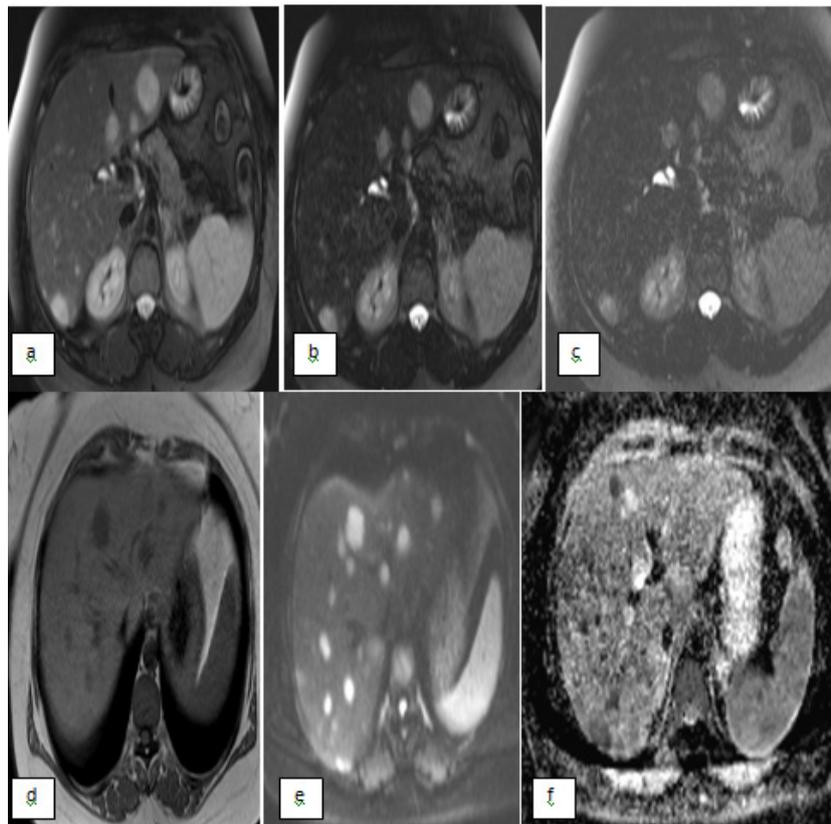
Increasing TET2 weighted images (a, b, c) in a patient with known carcinoma colon and a solitary lesion on USG. With increasing TE, the signal intensity of the lesions does not increase, indicating a solid lesion. T1 weighted image showing the lesions as hypointense in relation to liver parenchyma. DWI and ADC map showing additional lesions as well as strong diffusion restriction indicating metastatic nature of the lesions. The ADC value calculated in one of the lesion was 0.72×10^{-3} mm²/s
